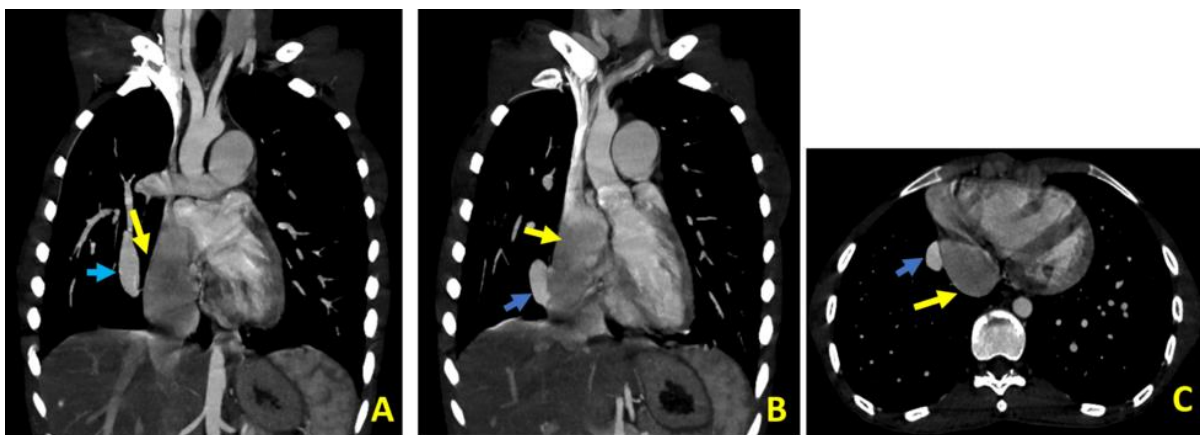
Coronal reconstruction CT (with 5 mm MIP) (A, B) and axial reconstruction (C) demonstrating the venous collector (Scimeter vein, blue arrow) descending along the right cardiac border towards the inferior vena which is dilated (yellow arrow)
